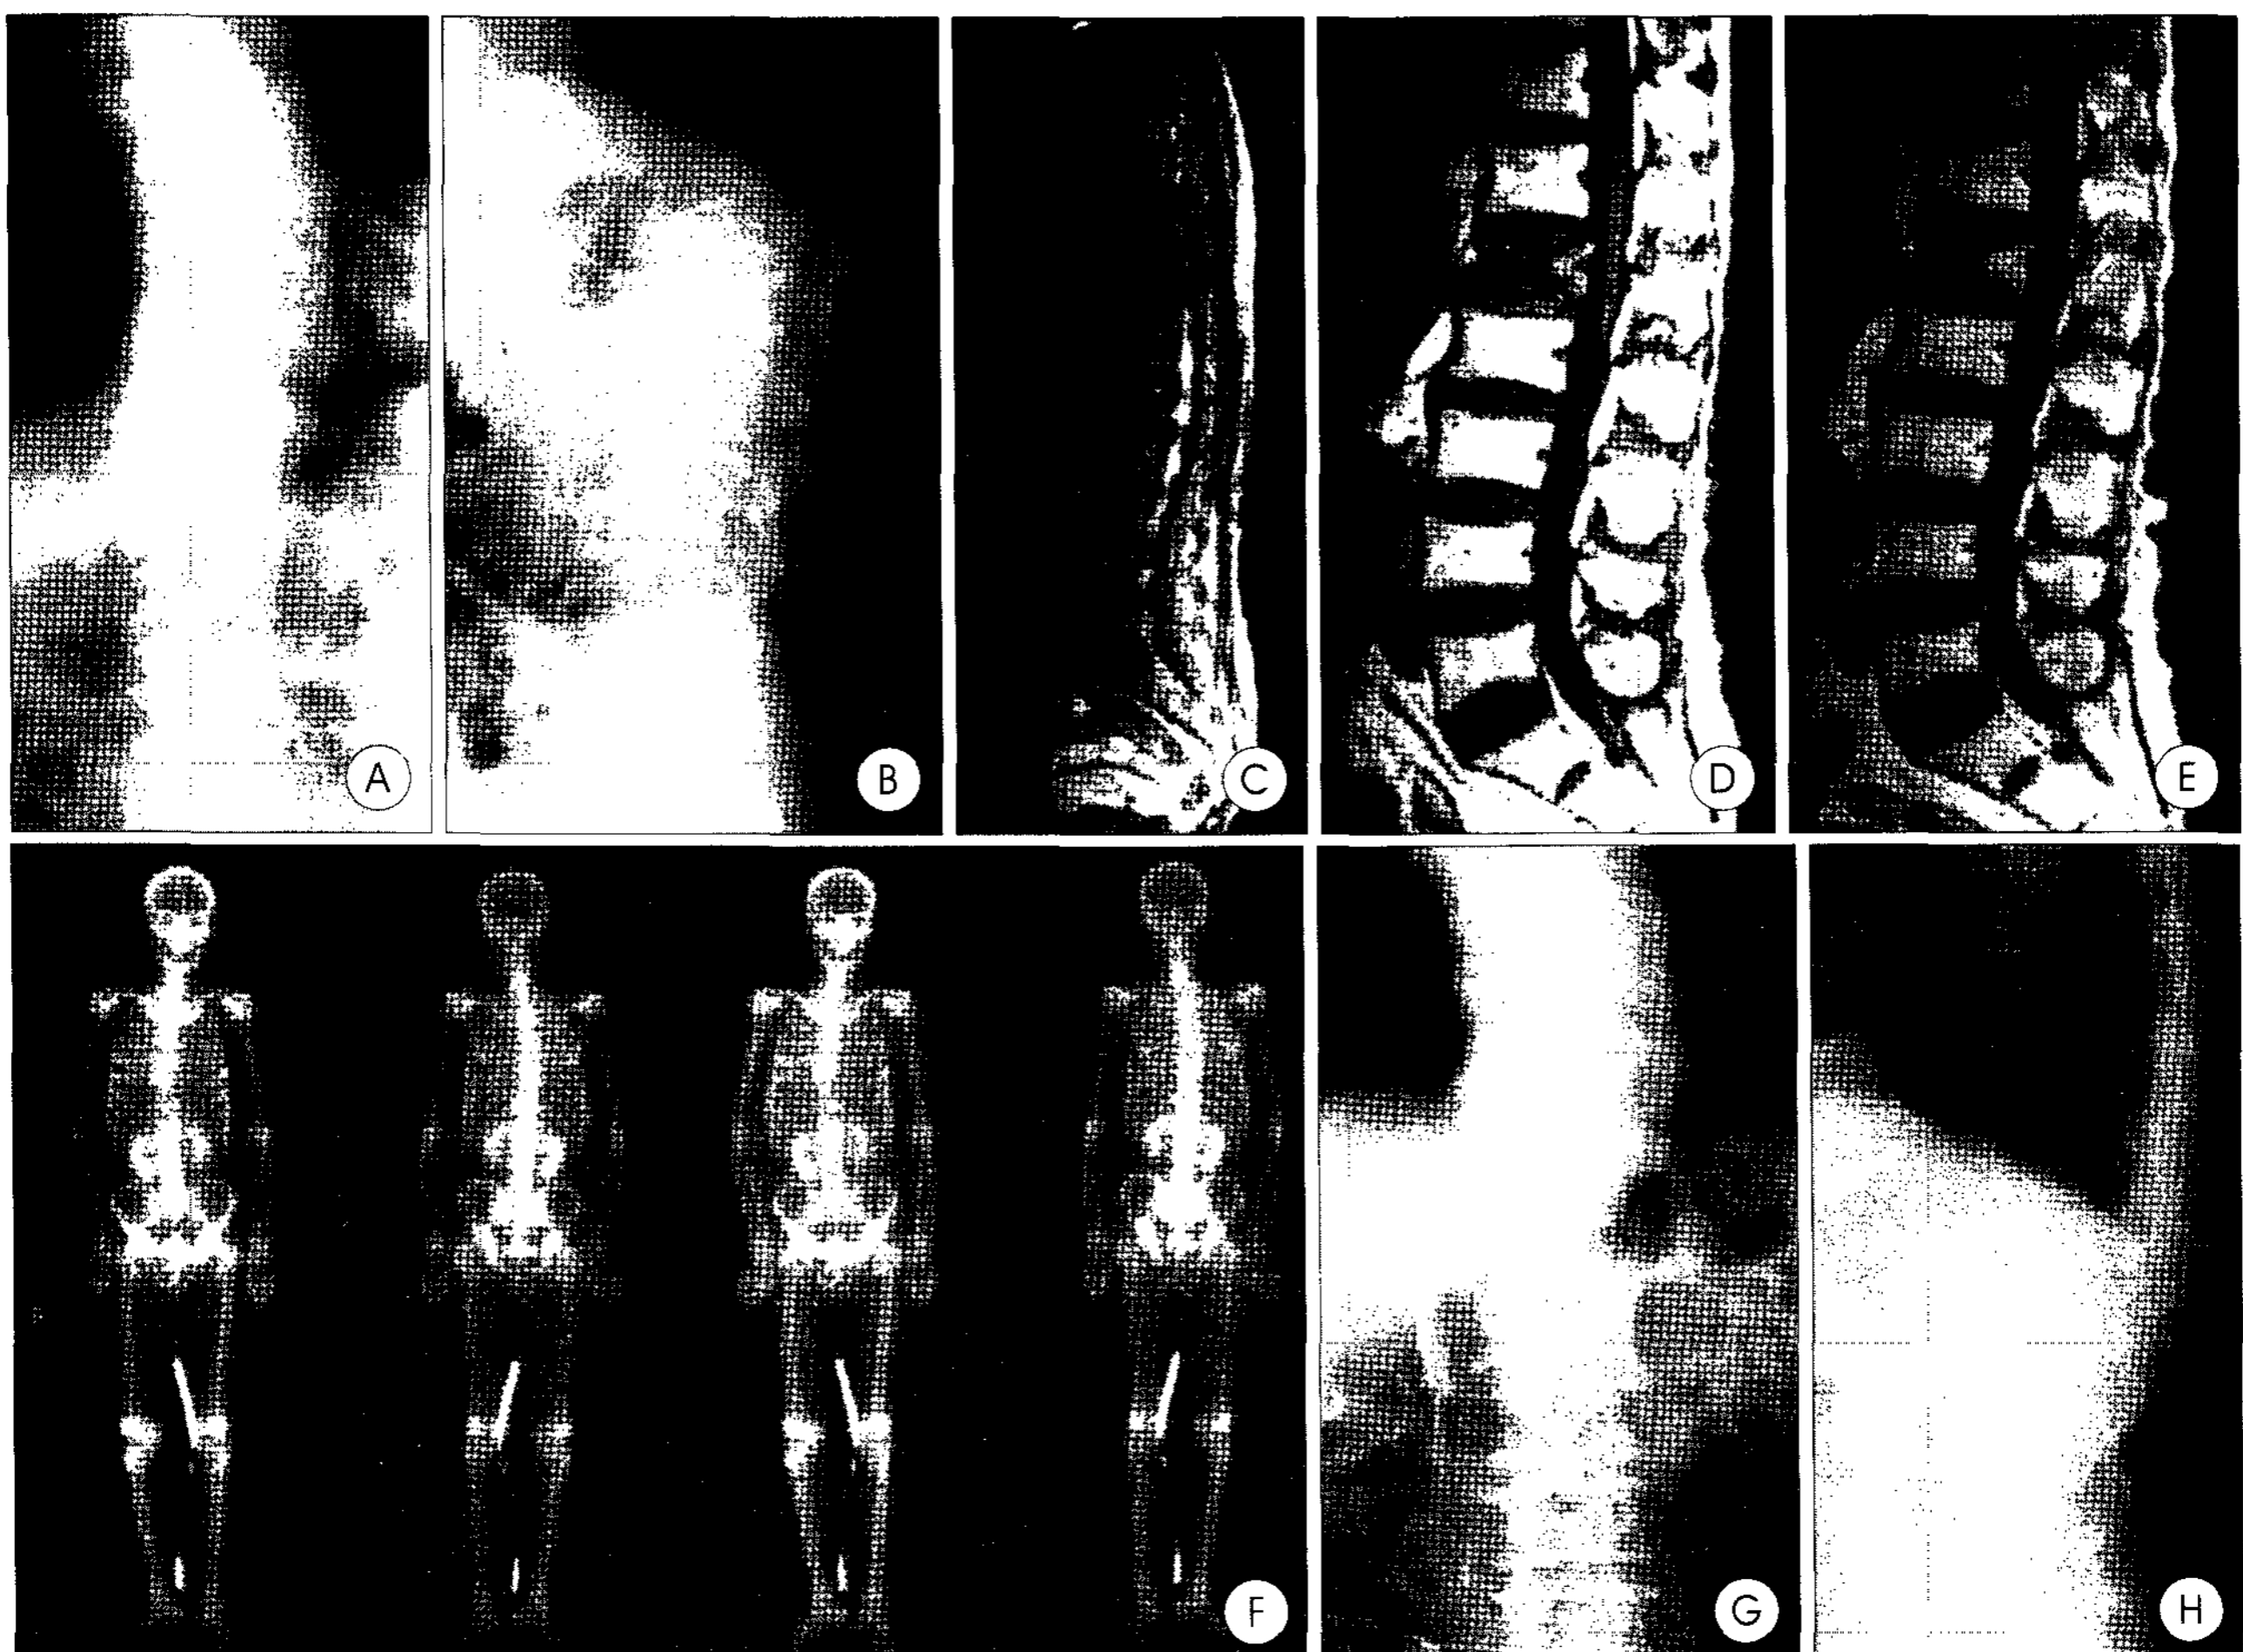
A 79-year-old man has suffered from persistently severe low back pain for 1 month. He has a past history of lung cancer. A, B : On plain X-ray demonstrating anterior wedging compression deformity and decreased vertebral body height of L1. C, D, E : Magnetic resonance image demonstrating low signal intensity at anterior vertebral body on T2 weighted image, low signal intensity on T1 weighted image, and slightly enhanced by gadolinium enhanced magnetic resonance image. F : Whole Body Bone Scan (WBBS) showing hot uptake on L1. G, H : Post operative X-ray.
